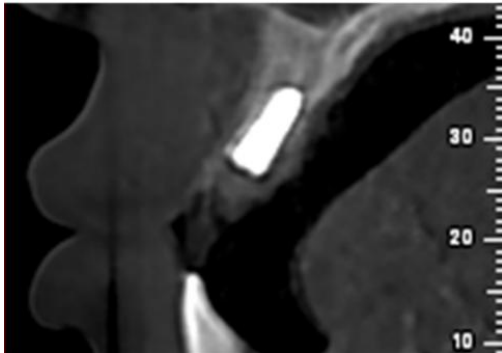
Postoperative CBCT
